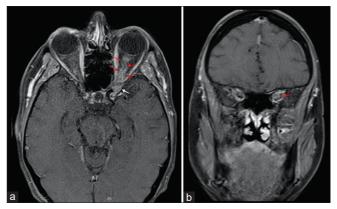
Axial (a) and coronal (b) T1-weighted postcontrast magnetic resonance imaging of the orbits with fat suppression demonstrating multifocal abnormal enhancement of the posterior left optic nerve sheath (red arrows) and anterior clinoid process (white arrow)
